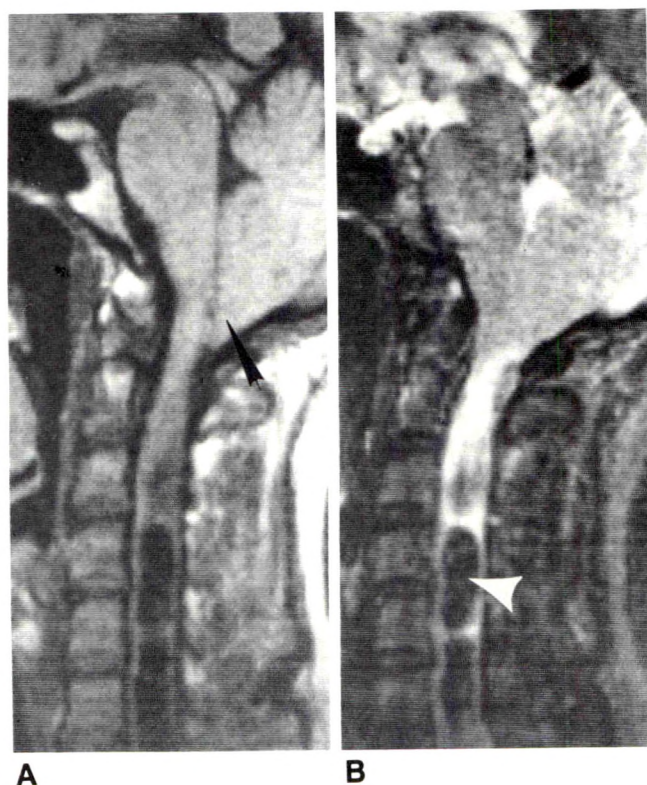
46-year-old woman with Chiari I malformation and syringomyelia. Note "beaded" shape of syrinx cavity. A, SE 500/40. "Pointed" tonsil below foramen magnum (arrow). B, SE 3000/120. "Beaded" shape is more noticeable on this T2-weighted image. Note CFVS in cavity (arrowhead). Increased intensity present at rostral end of syrinx may represent gliosis.
